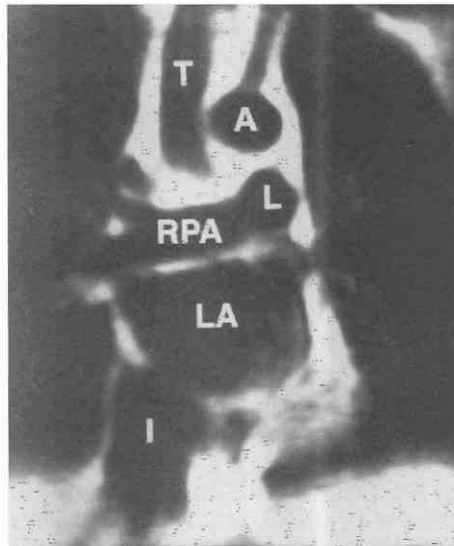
Coronal MR image at the right pulmonary artery level. A, aorta; I, inferior vena cava-right atrial junction; L, left pulmonary artery; LA, left atrium; RPA, right pulmonary artery; T, trachea.
